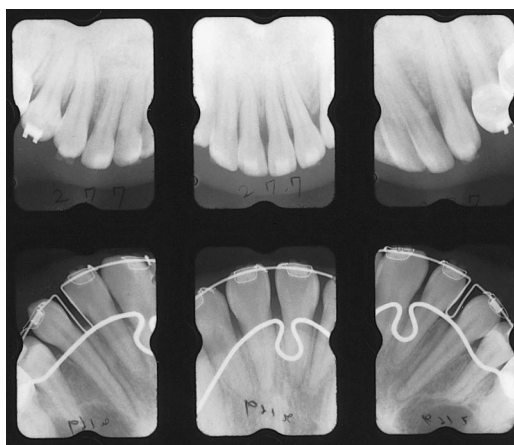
Periapical radiographs (before *en masse* movement).
